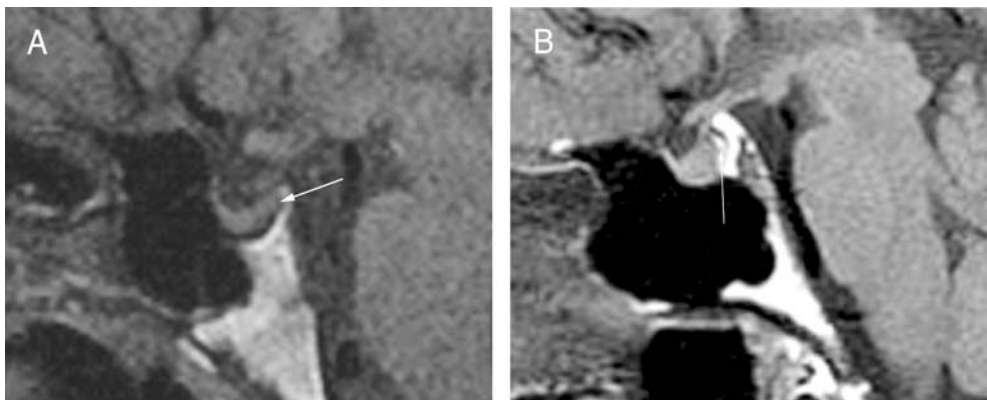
Non-enhanced sagittal T1 MRI of the sella turcica shows (A) absence of the neurohypophysis hyperintense signal (arrows). For comparison a normal MRI of the sella turcica is shown (B)
